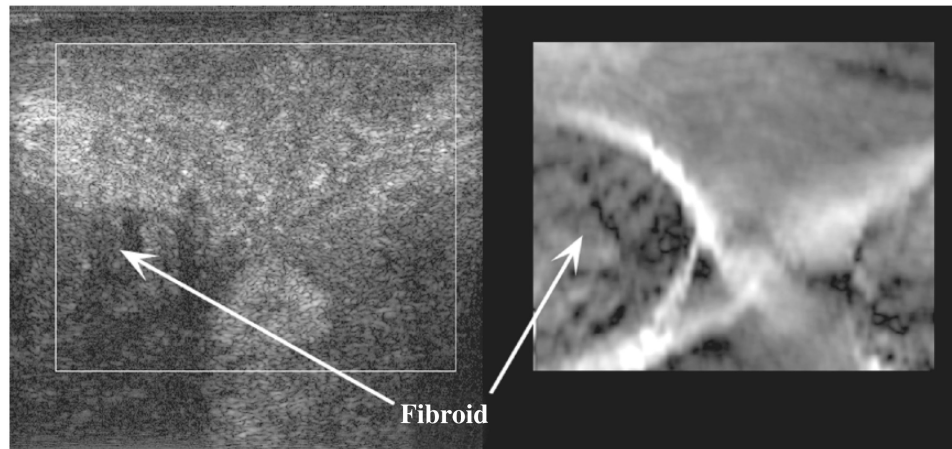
Side-by-side comparison of an ultrasound B-mode image with the corresponding elastogram of an excised uterus from a 51-year-old patient. The width of the B-mode image is 5 cm. The location of the fibroid is indicated by the arrow.
